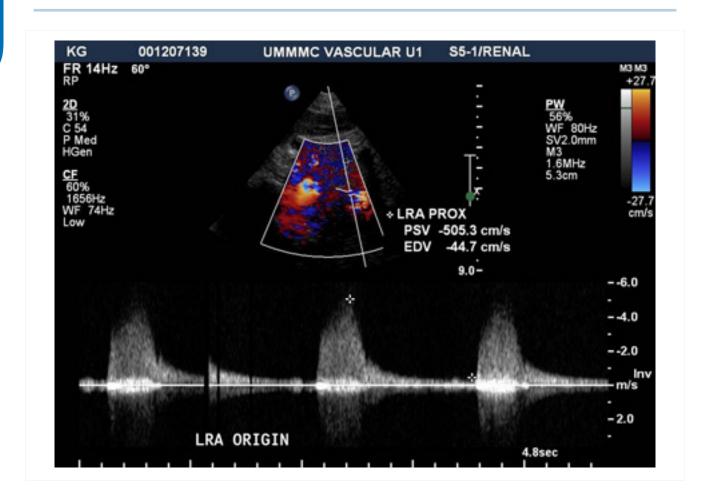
Colour and spectral Doppler of the left renal artery show colour disturbance due to turbulence, and an increased velocity of 50 m/second across a stenotic segment in the proximal left renal artery, consistent with significant renal artery stenosis
